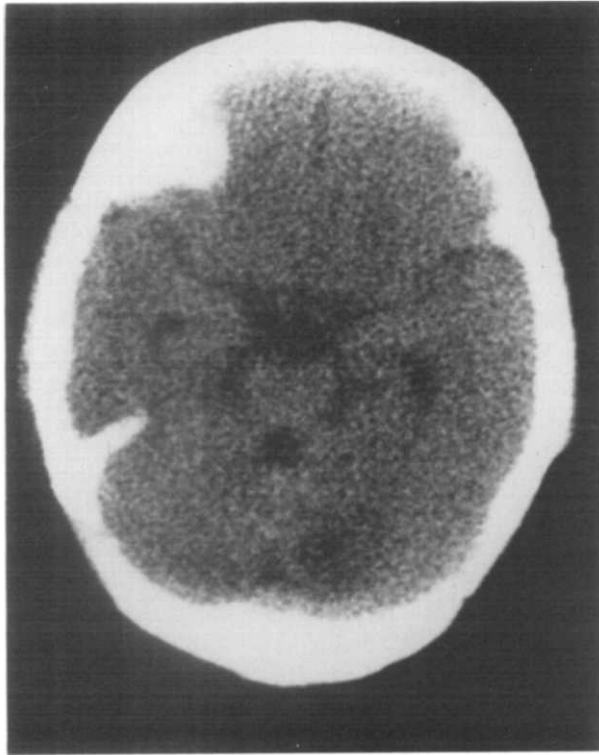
Unenhanced CT of a 2-month-old infant with a previously diagnosed neonatal cerebellar hemorrhage, now revealing a low density lesion in the left cerebellar hemisphere and mildly enlarged fourth ventricle suggesting loss of brain substance.
